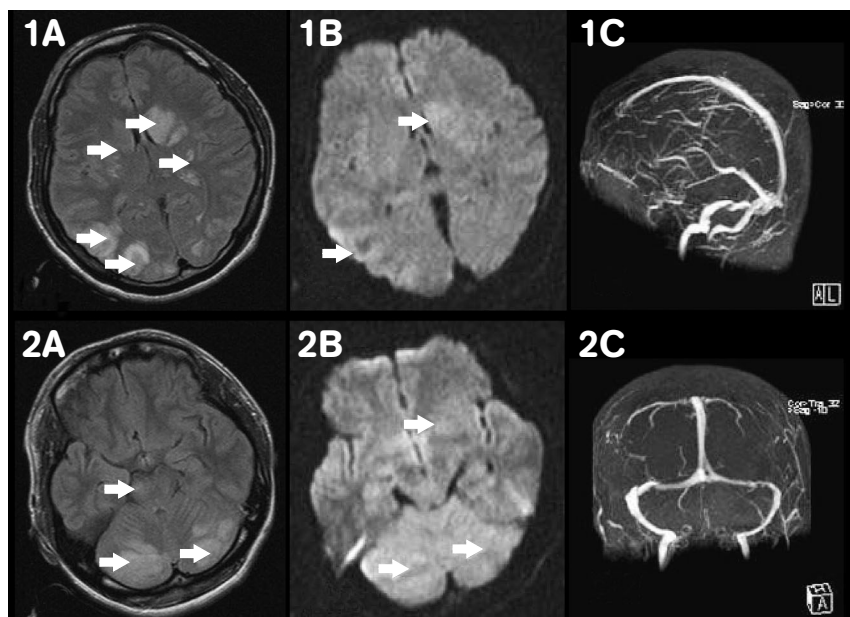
The first head MRI revealed multiple high signal-intensity lesions on FLAIR/T2WI in the head of caudate nucleus, bilateral putamen & corona radiata, centrum semiovale, bilateral parieto-occipital gyrus, midbrain-pontine area, bilateral cerebellum (white arrows in Figs. 1A-2A) and mild high signal-intensity lesions on DWI (white arrows in Figs. 1B-2B). These pictures favor a process of vasogenic edema rather than cytotoxic edema is considered. No evidence of sinus thrombosis was noted under the MRV study (Figs. 1C-2C).
